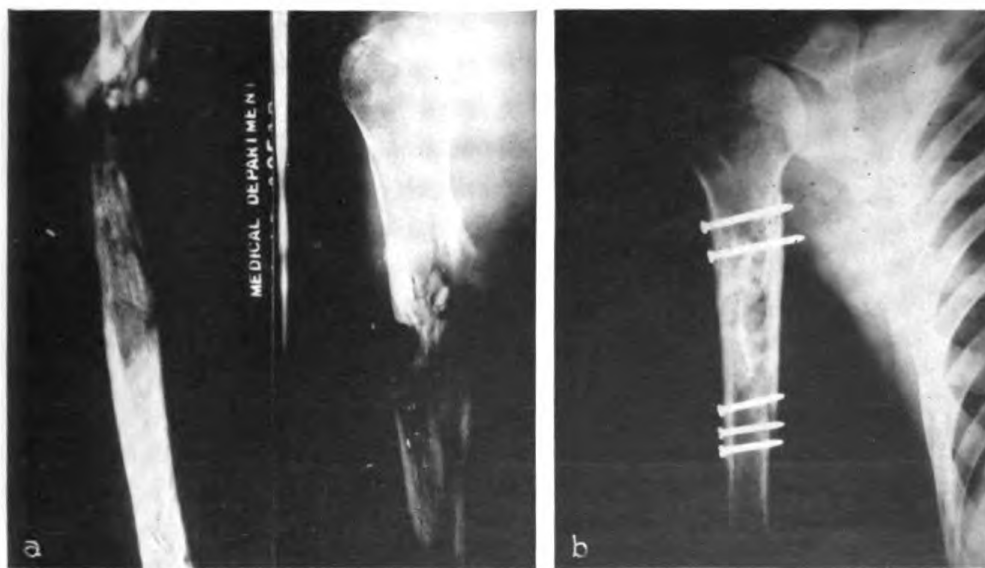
(a) Compound fracture of the humerus. The nonunion was repaired by an onlay tibial bone graft 5 months after the original injury. (b) Roentgenogram taken 5 months after grafting demonstrates solid union.
